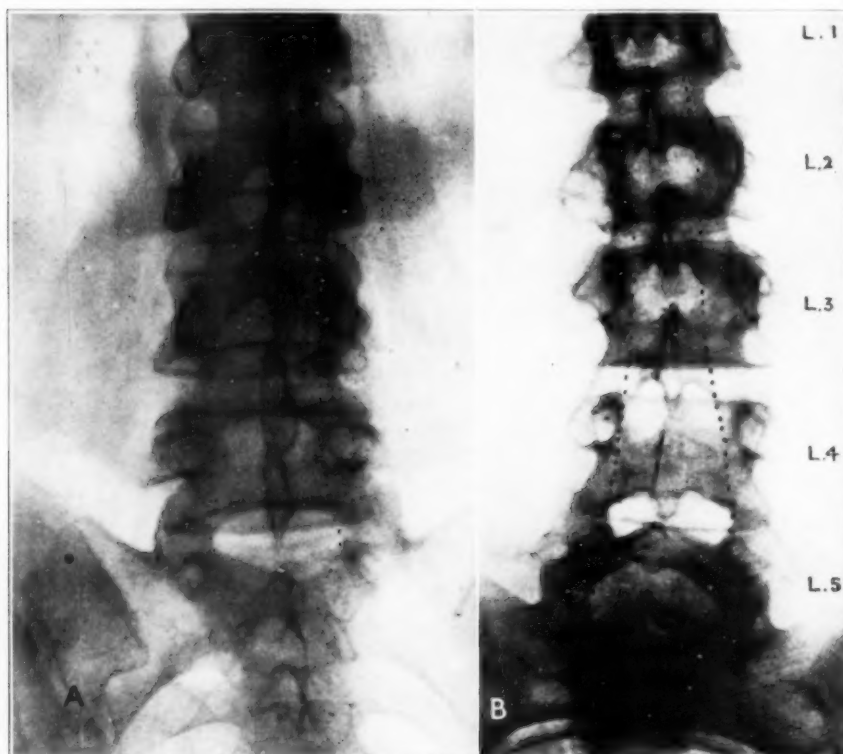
A*, roentgenogram, showing enlargement of the lumbar vertebral canal in a case of large tumor of the cauda equina; *B*, enlargement of the vertebral canal in the fourth and fifth lumbar vertebrae in a patient (case 1) with a large caudal tumor.
